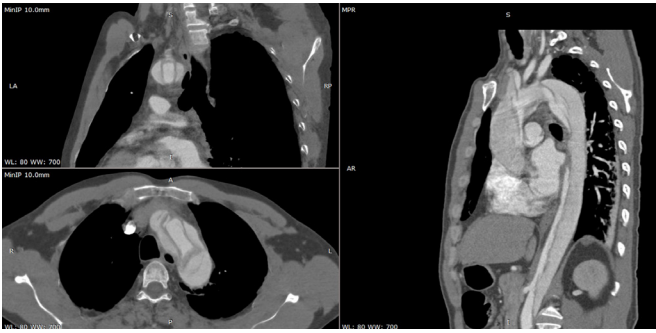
Preoperative CT scan showing acute type A dissection.
